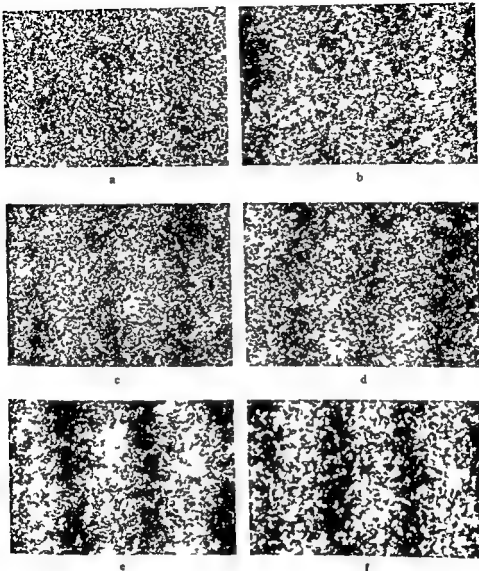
Magnified grid images displaying the effect of the copying procedure where a grid image on a double-emulsified film is contact copied onto a single-emulsified fine grained film. Single emulsified roentgen films have been used to analyse the two layers of the double-emulsified film separately. a) Magnification of a single-emulsified film with grid image without previous copying. b) c) Single emulsified film copied onto Agfa Gevaert Graphic film N 33 the emulsion in contact with and turned away from the N 33 film respectively. d) Double-emulsified film copied onto N 33. e) f) Same as (c) and (d) but using Kodak Ortho Type 3 instead of N 33. In (a) the inherent granularity of the original film makes evaluation of the density fluctuations almost impossible. d) demonstrates the joint effect of the varying degree of filtration of the two emulsions (b and c) at the copying. The best recording of the density fluctuations (macroscopic mottle) is obtained with the Kodak film, probably due to its higher contrast and finer grain. Kodak X-omatic screens and Curix RP 1 have been used for the original grid images.
